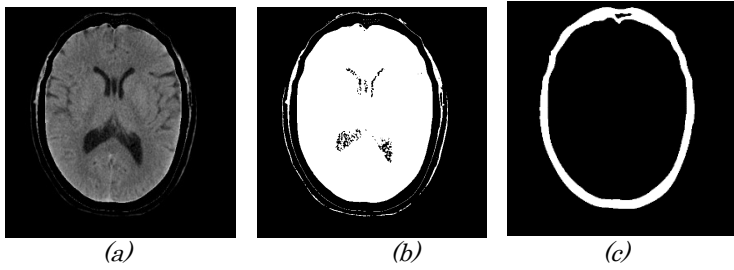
(a) Skull removed brain CT scan [83], (b) its equivalent image and (c) Skull image
